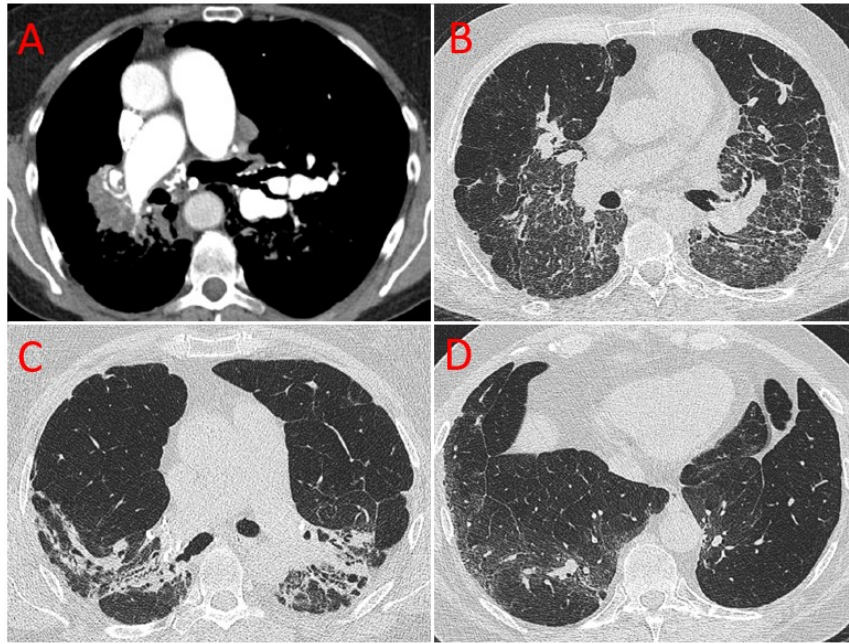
High resolution CT dicoms from three different patients with Sarcoid from the ILD-PH cohort.
